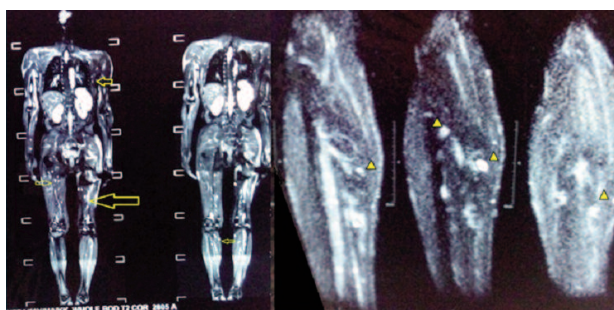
Magnetic resonance imaging whole body T2 weighted screening and MRI of bilateral lower limbs showing hyperdense lesions (yellow arrows and arrowheads)
